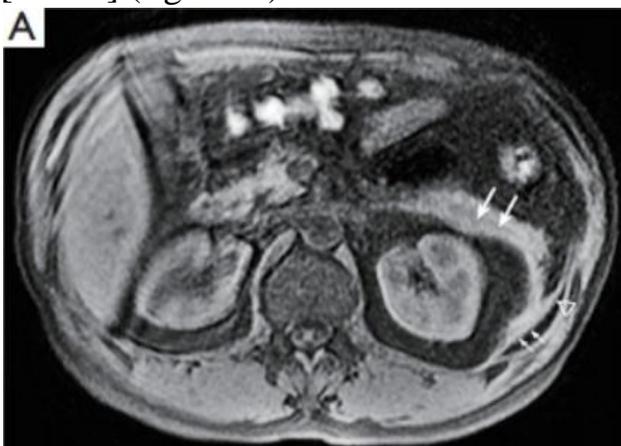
A 36-year-old patient with acute pancreatitis. Inflammation is defined in the left half of the mesentery root (long arrows), left posterior space (short arrows) and left paracolic space (triangle) as an isointense signal on the T1-weighted image without contrasting (A) and hyperintense zones on the T2-weighted image (B) Without fat suppression and using the technique of suppression of the signal from the adipose tissue (C)
